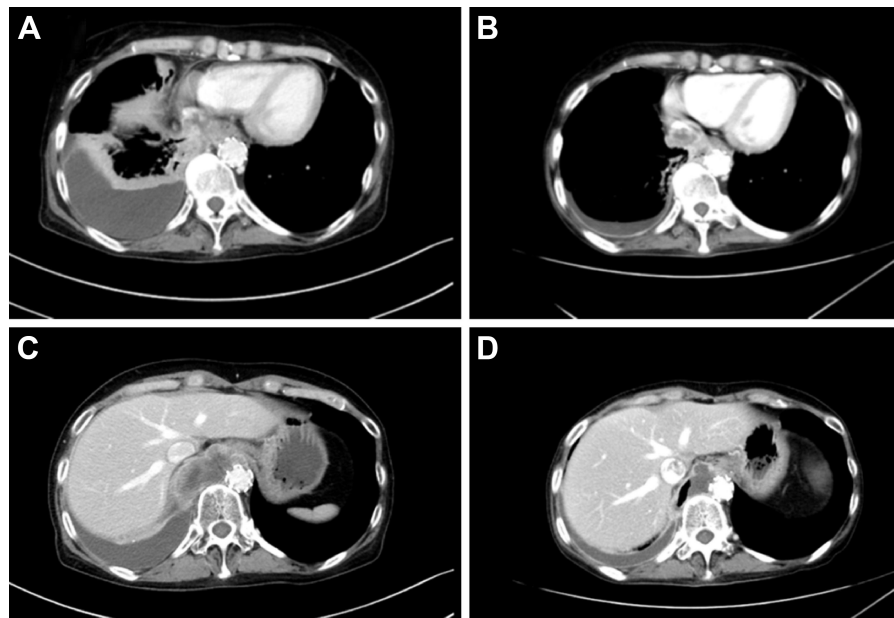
CT scan before introducing ceritinib (A, C), and 6 weeks after treating with ceritinib (B, D). Reduction of the primary tumor and plural effusion was revealed after the treatment.
